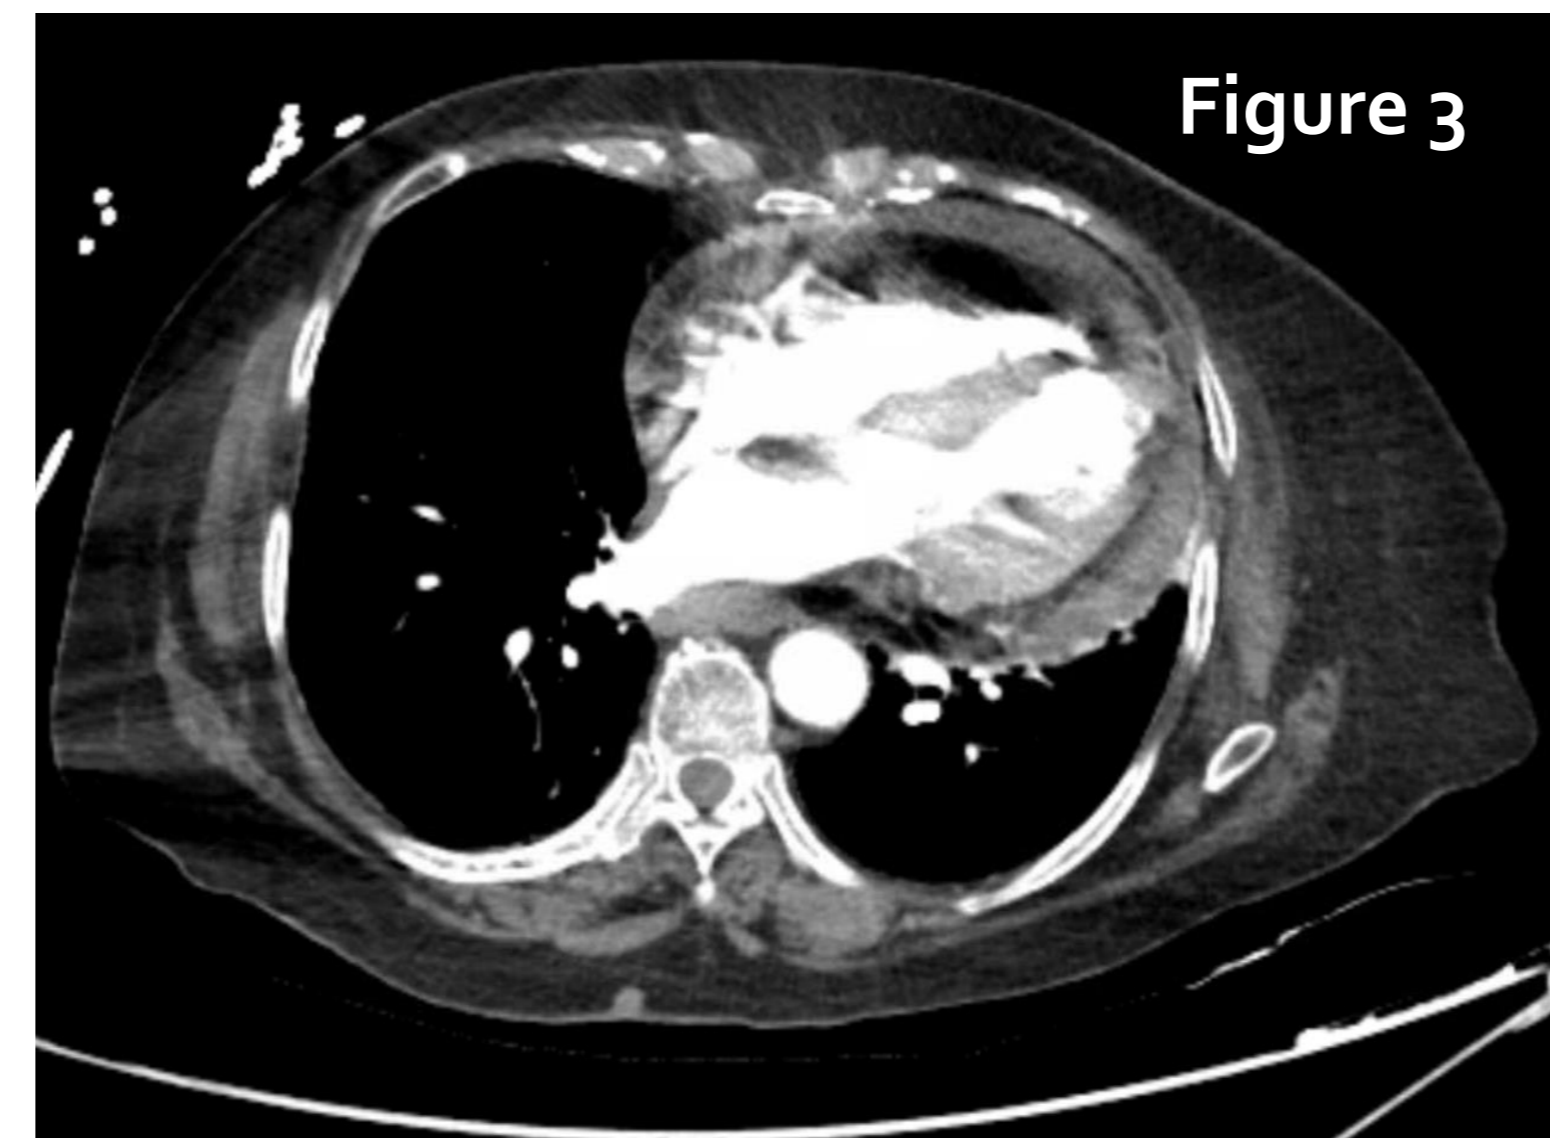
CT chest angiogram showing complex pericardial effusion compatible with hemopericardium.
